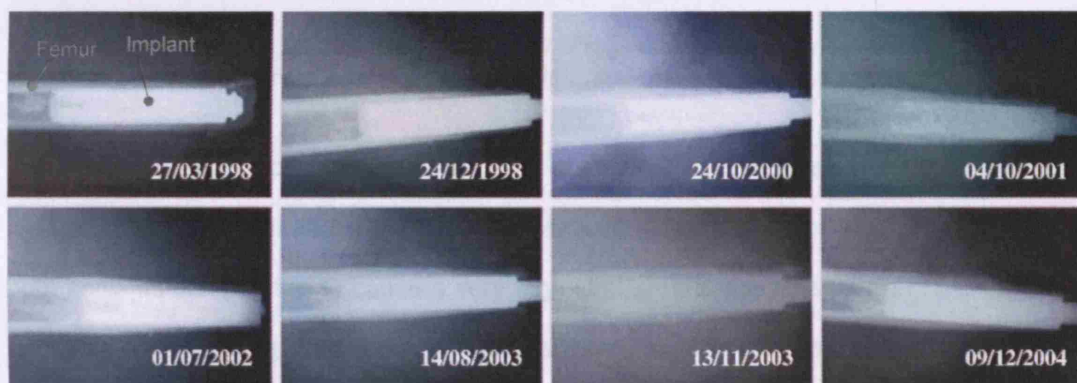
Radiographs of a femur implanted with the OPRA implant over seven years adapted from Xu and Robinson, 2008.
